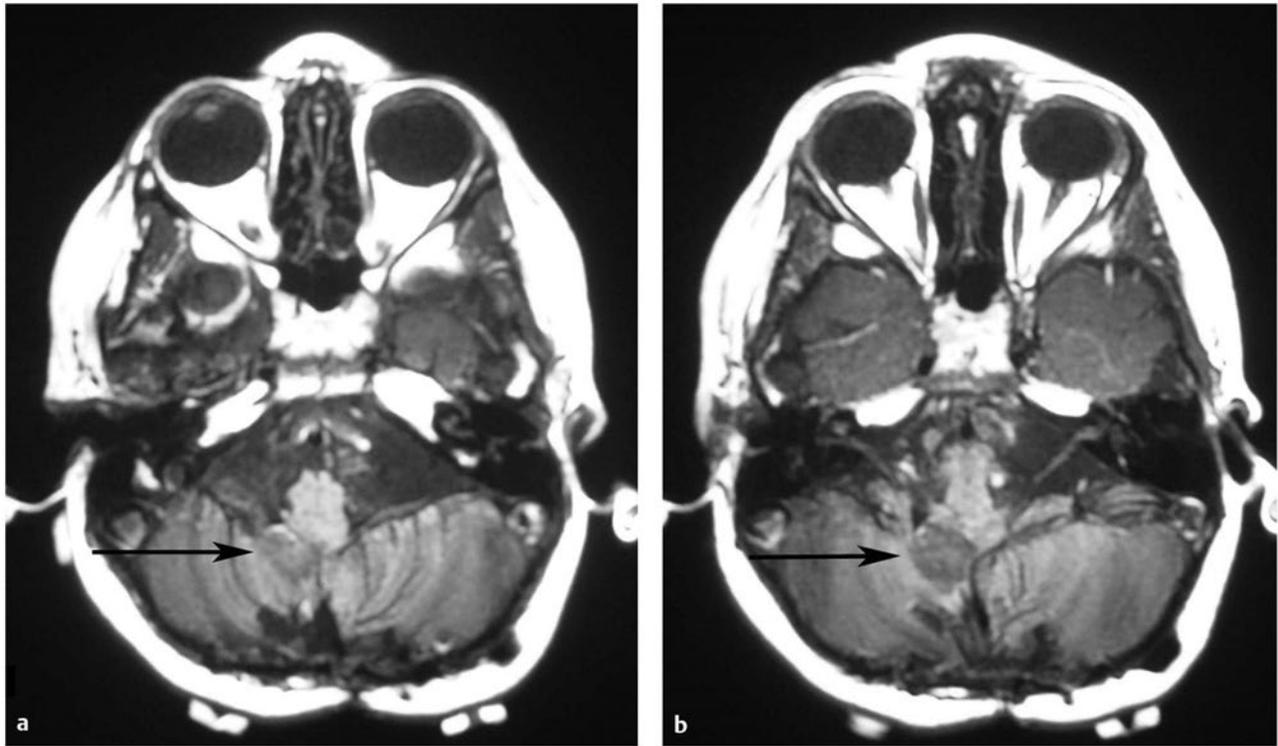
Residual ependymoma after a first resection. (a,b) Postoperative magnetic resonance images after resection of a pediatric posterior fossa ependymoma show a small amount of nonenhancing residual tumor in the right foramen of Luschka. This residual tumor was resected at a repeated craniotomy, yielding a gross total resection.
